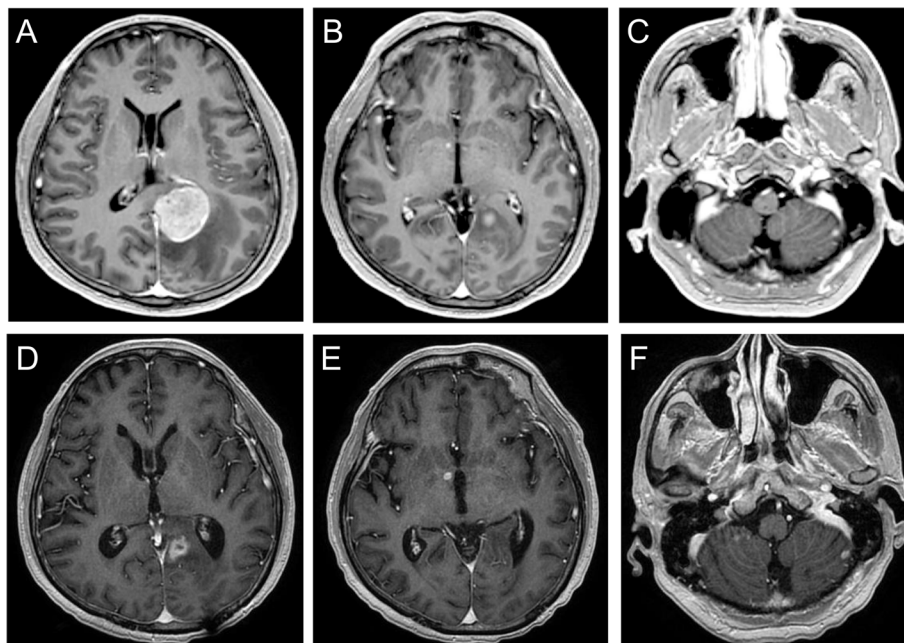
T1-weighted gadolinium-enhanced brain MRI of a 64-year-old man. Oligoprogression lesions were noted in left occipital lobe (A), right basal ganglia (B), and left cerebellum (C). The patient continued afatinib after surgically removing the left occipital tumor with adjuvant WBRT. After a 6-month follow-up, the tumor was controlled in the left occipital (D) but progressed in the right basal ganglia (E) and left cerebellum (F)
